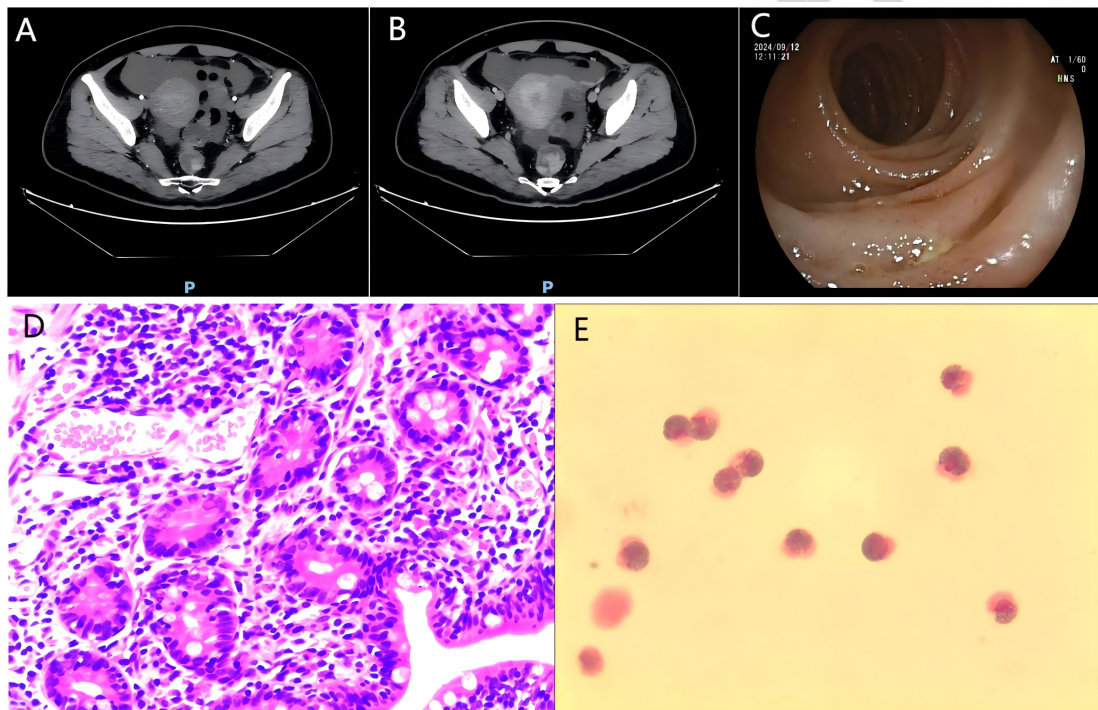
Abdominal contrast CT showed massive ascites with mucosal thickening and dilatation of jejunum and ileum (Figures A and B). Double-balloon enteroscopy showed disseminated hyperemia and edema in all duodenum, jejunum and ileum mucosa (Figure C). Biopsies from the small bowel revealed inflammation with eosinophil marked infiltration (Figure D). Pathological examination of ascites revealed plentiful eosinophils with a count of 3600 (Figure E).
